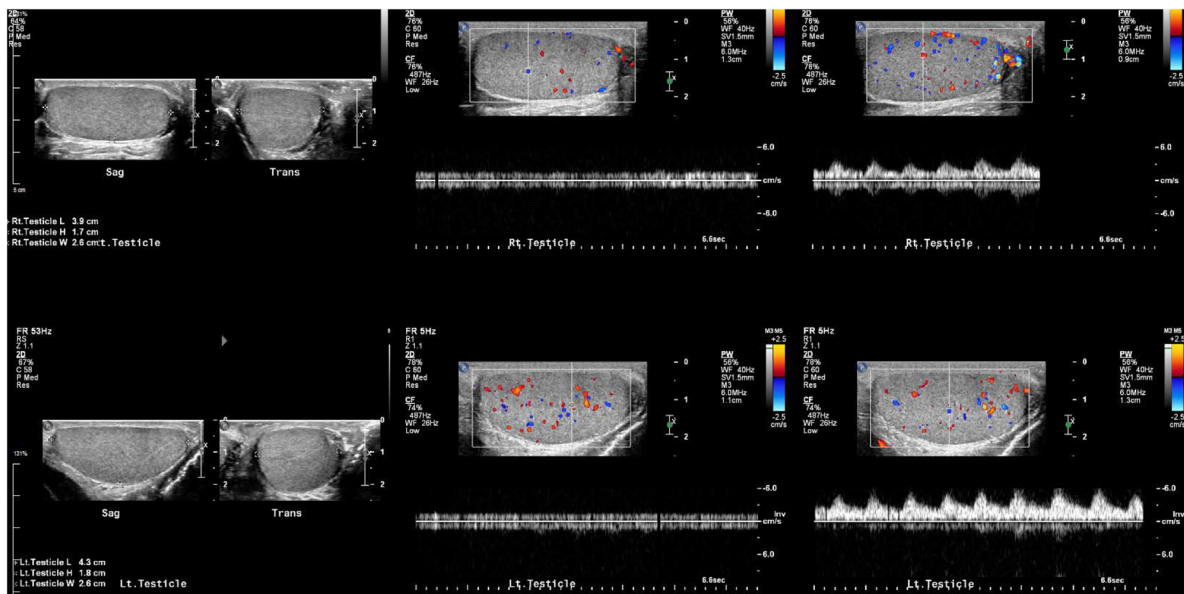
The testicles should be evaluated by both gray-scale and color Doppler ultrasound. Spectral Doppler assessment is necessary to demonstrate arterial and venous flow. Color and spectral Doppler is necessary to demonstrate vascularity as well as arterial and venous flow. (Color version of figure is available online.)
